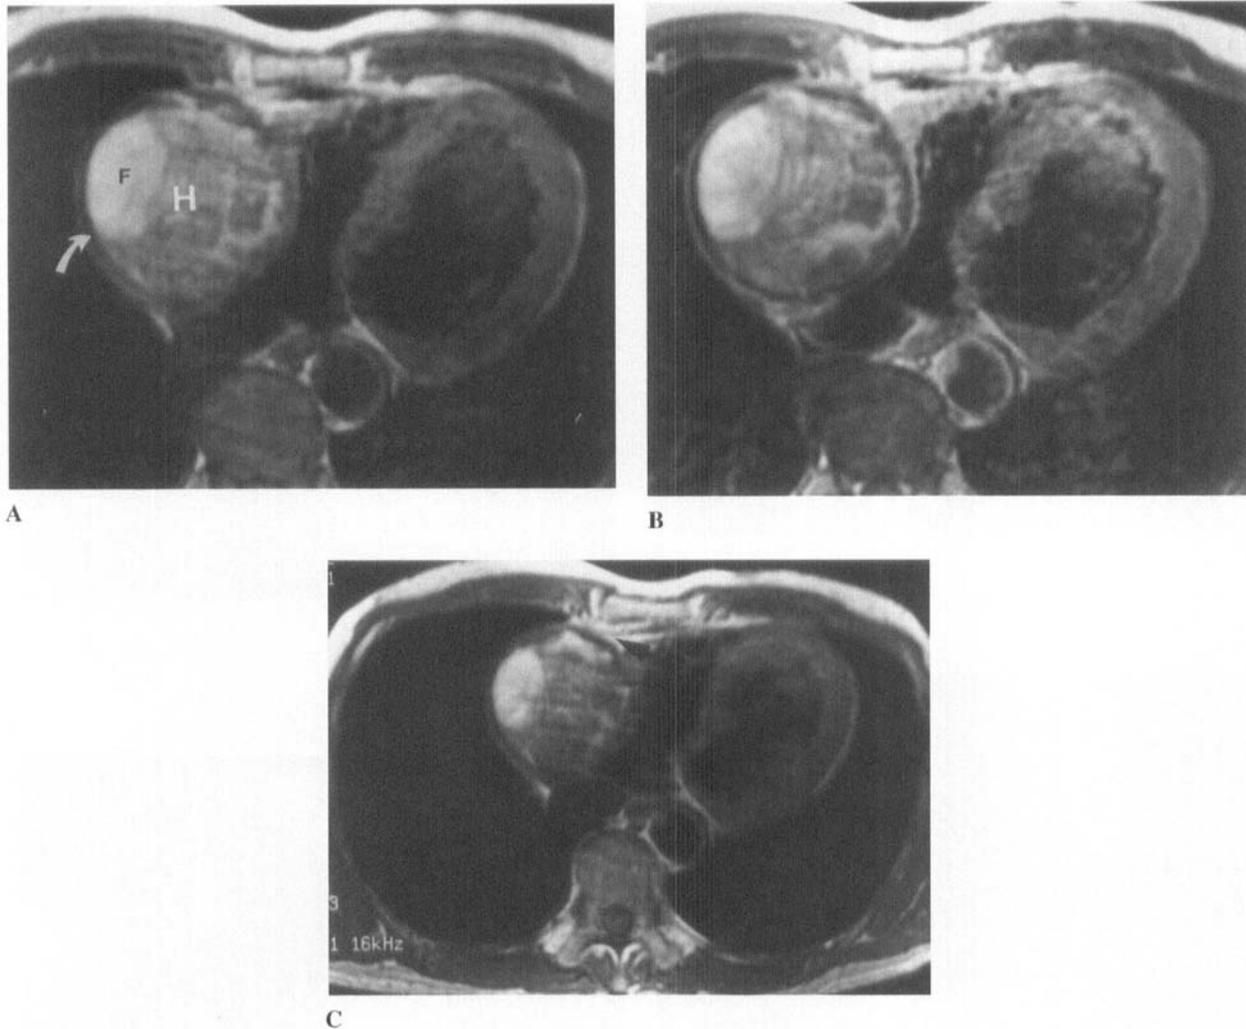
Patient 2: A 69-year-old man with a history of RCA angioplasty, who developed a pericardial hematoma (H) in the right atrioventricular groove. (A) Axial SE T1-weighted image (TR 923, TE 20) demonstrates a heterogeneous mass with areas of high signal intensity, likely hemorrhagic fluid (F), and internal dark foci and a low signal intensity rim (arrow) suggestive of calcification, which was seen on chest radiographs. (B) Axial SE T1-weighted image (TR 952, TE 20) after administration of Gd-DTPA shows that the mass does not enhance. (C) Axial SE T1-weighted image (TR 923, TE 20). The pericardial location is established by the acute angle formed by the junction of the mass and the pericardium (arrow).
